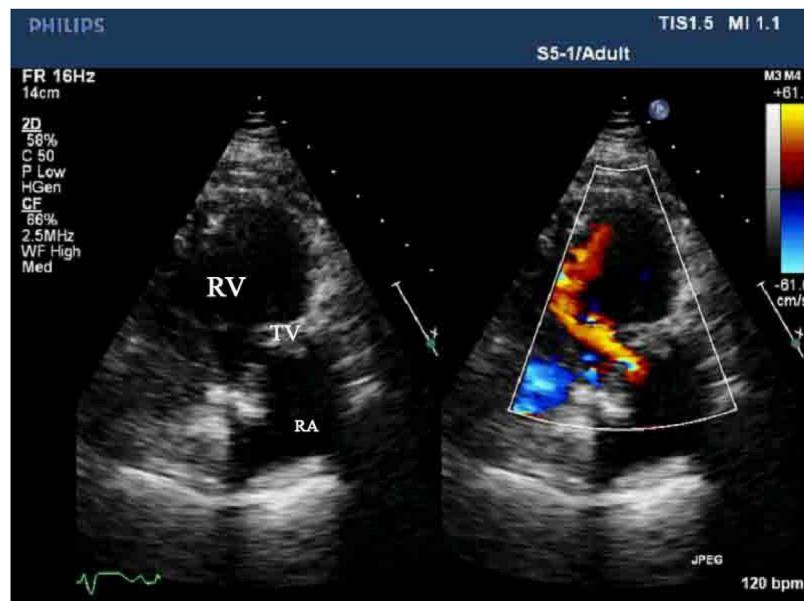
Transthoracic echocardiography (TTE) demonstrate bioprosthetic tricuspid valve and the color Doppler show narrow right ventricular inflow jet produced by the thrombosed tricuspid prosthesis (RA, right atrial; RV, right ventricle; TV, tricuspid valve).
